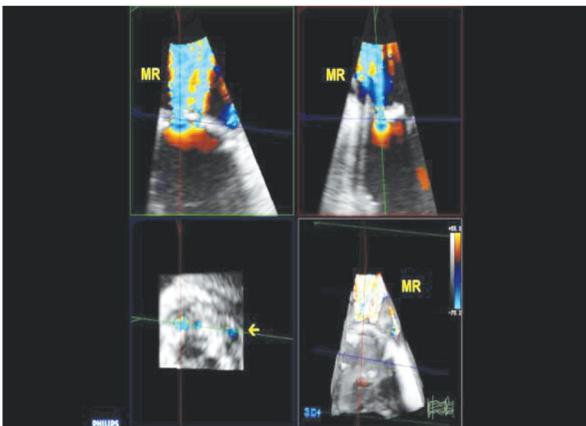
Three-dimensional transesophageal color Doppler en face view of a mitral valve prosthesis showing the location of 3 separate paravalvular leaks (arrow). Quantitative assessment of leakage size using three-dimensional analysis software and multiplanar reconstruction (MPR) mode. MR- mitral regurgitation
